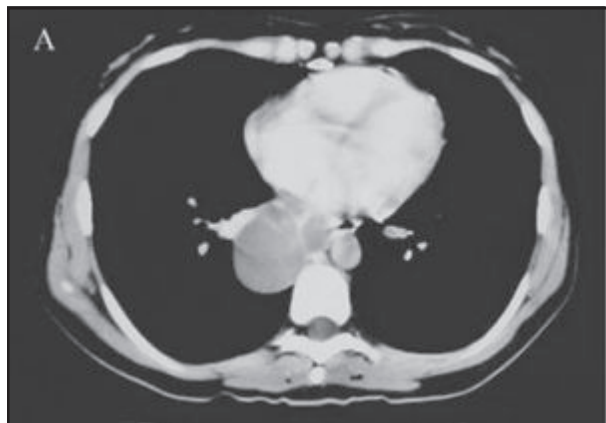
CT scan of Bronchogenic cyst
